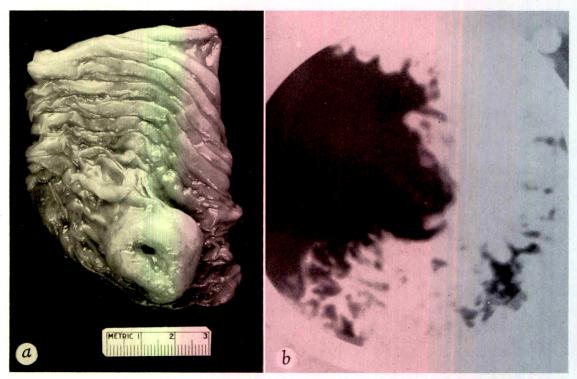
(a) Intramural leiomyoma with small ulcer of overlying mucosa. Crater extends into mass of tumor. (b) Spot roentgenogram showing typical intramural filling defect with niche of ulcer extending into it.
